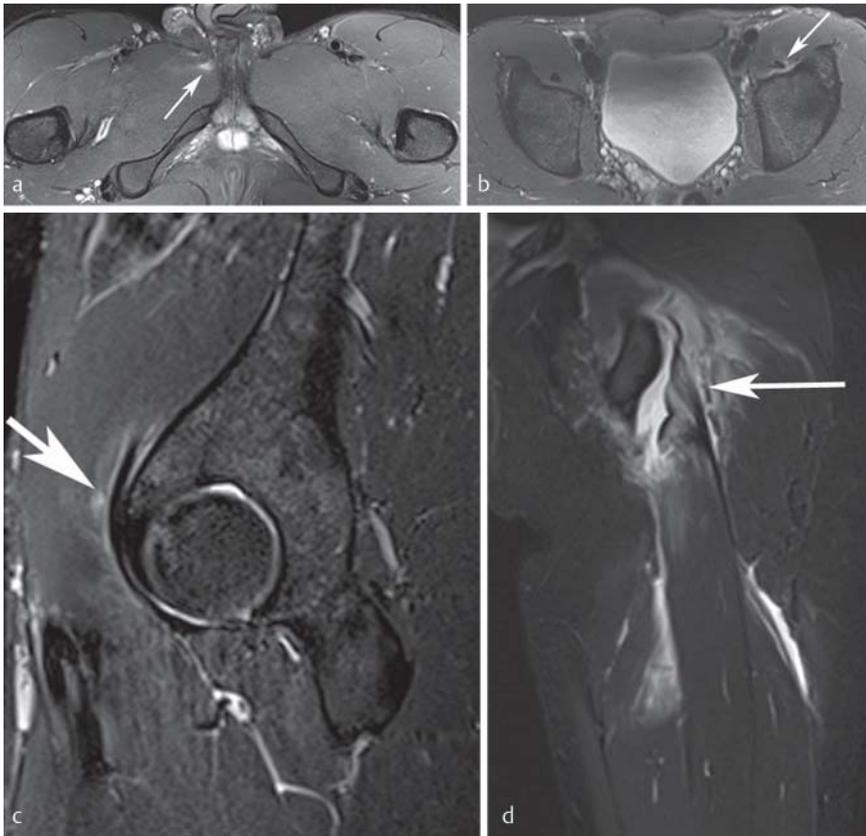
Overview of muscle tears with varying degrees of severity in the vicinity of the pelvis. a The axial fat-suppressed T2-weighting shows a grade 1 tear according to [19] of the right adductor magnus muscle (arrow) in a 20-year-old professional soccer player. b, c Grade 1 tear according to [19] of the left iliopsoas muscle on the myotendinous junction (arrow) in a 30-year-old professional soccer player (b, axial fat-suppressed T2-weighted; c, sagittal STIR sequence). d Grade 3 muscle injury according to [19] after a split during a dance performance of a 15-year-old girl with detachment of the biceps femoris muscle on the ischial tuberosity. The arrow on the coronal STIR sequence points to the detached tendon end and the hematoma.
